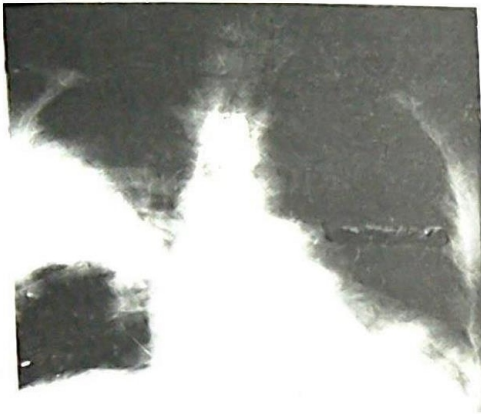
Chest x-ray of 32 year old male subject with HIV/PTB co-infection. Initial chest x-ray showed a homogenous opacity of the axillary segment of the right lower lobe. There is also hazy opacity of the left lower zone obliterating the hemidiaphragm. The presence of silhouette sign makes this a consolidation rather than pleural fluid collection.
